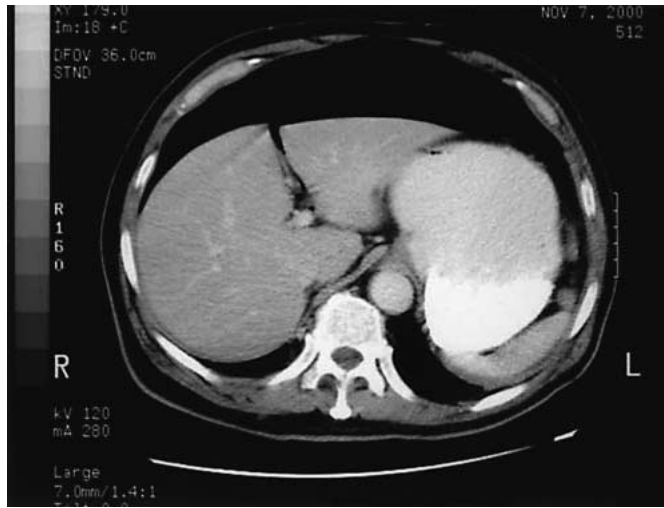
Abdominal CT scan of the patient 4 weeks after surgery.
